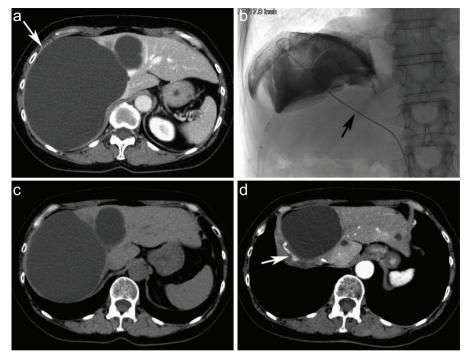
a-d. A 60-year-old woman with a large cyst in the right hepatic lobe. Enhanced CT (a) shows a large cyst in the right hepatic lobe (*arrow*). A small cyst is also seen adjacent to the large cyst. This patient has a history of surgical intervention for large hepatic cysts. Spot radiograph obtained during sclerotherapy using 40 mL of 5% EO after aspiration of 1800 mL of the fluid content (b) shows a large cyst. The *arrow* indicates a 4 F pigtail catheter. Unenhanced CT performed 3 months after sclerotherapy (c) shows that the density of the treated cyst contents is slightly elevated. The percentage reduction of the estimated cyst volume is 39.5%. Enhanced CT performed 3 years after sclerotherapy (d) shows that the cyst is organized with calcification (*arrow*). The neighboring cyst is enlarged.
